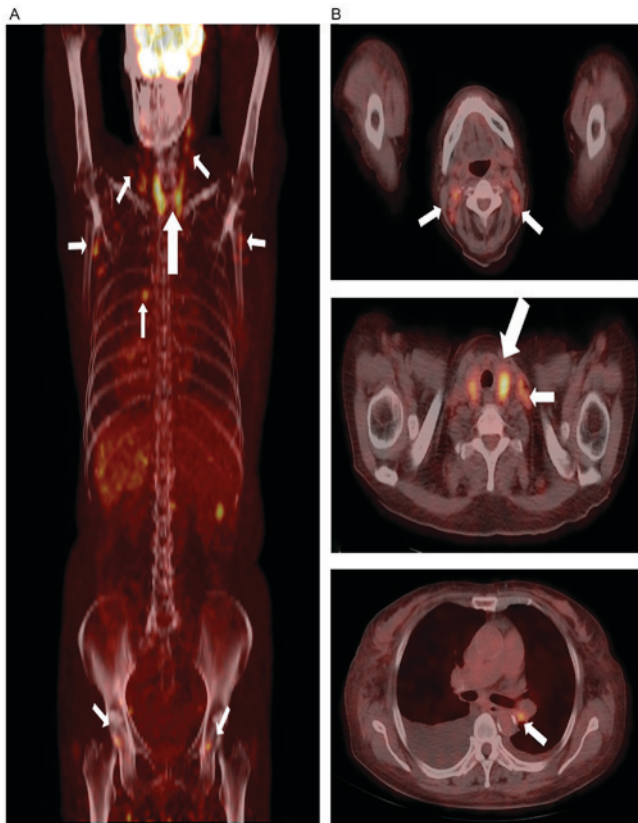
(A) Coronal FDG PET/CT image of the patient in case 1. (B) Axial FDG PET/CT images of the patient. The images revealed the presence of ^{18}F -FDG uptake in the lesions of the bilateral neck, bilateral axillary, mediastina and bilateral inguinal regions (smaller white arrows). The SUV_{max} of these lymph nodes was 3.8, and the presence of malignant lymphoma was suggested. In addition, the images revealed another lesion with increased FDG uptake (SUV_{max} , 3.6) in the neck region (large white arrows); however, the nature of this lesion could not be determined. FDG PET/CT, F-fluorodeoxyglucose positron emission/computed tomography; SUV, standard uptake value.
